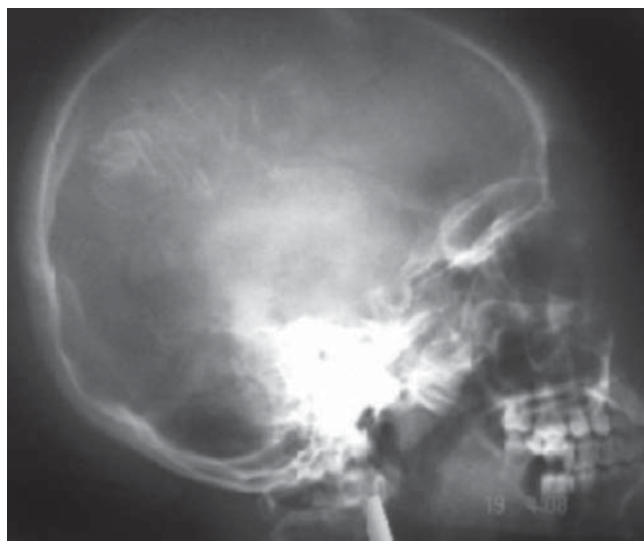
Sturge-Weber syndrome. Note the rail-track (tram-track) calcification in the frontoparietal region in skull X-ray.
